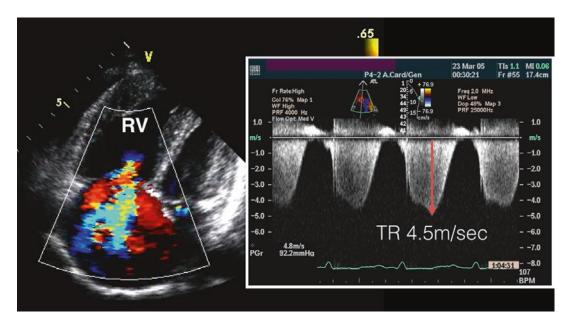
Four-chamber view (left) with significant tricuspid regurgitation. On the right, using continuous wave Doppler the maximal TR velocity can be measured. In this
